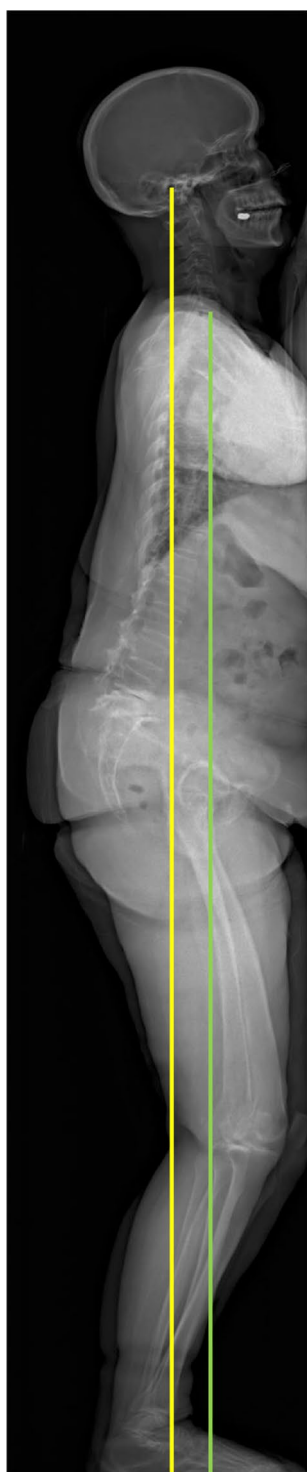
Radiographic assessment of global sagittal alignment on standing biplanar low-dose X-ray imaging. Yellow line: center of the acoustic meatus-sagittal vertical axis; Green line: sagittal vertical axis
